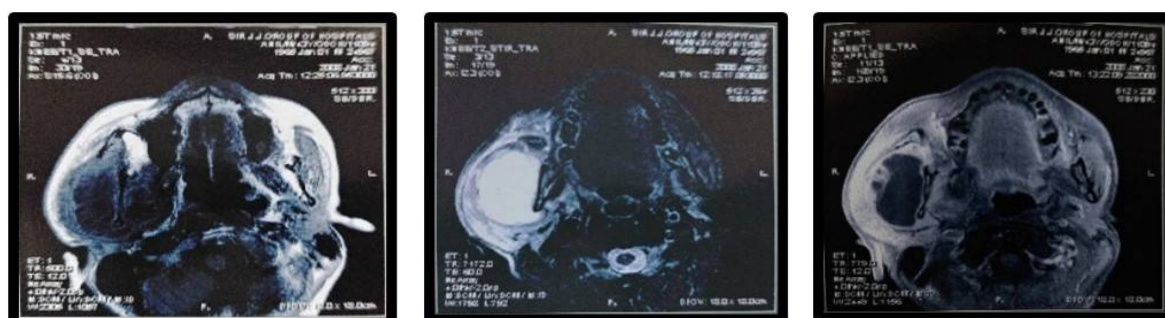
(a) T1 weighted axial section of MRI shows hypointense area on right side with involvement of lateral and medial pterygoid muscle and parotid gland (b) STIR axial section of MRI shows hyperintense area on right parotid gland region (c) Post contrast T1 weighted axial section shows peripheral rim enhancement with displacement of masseter muscle superiorly.
